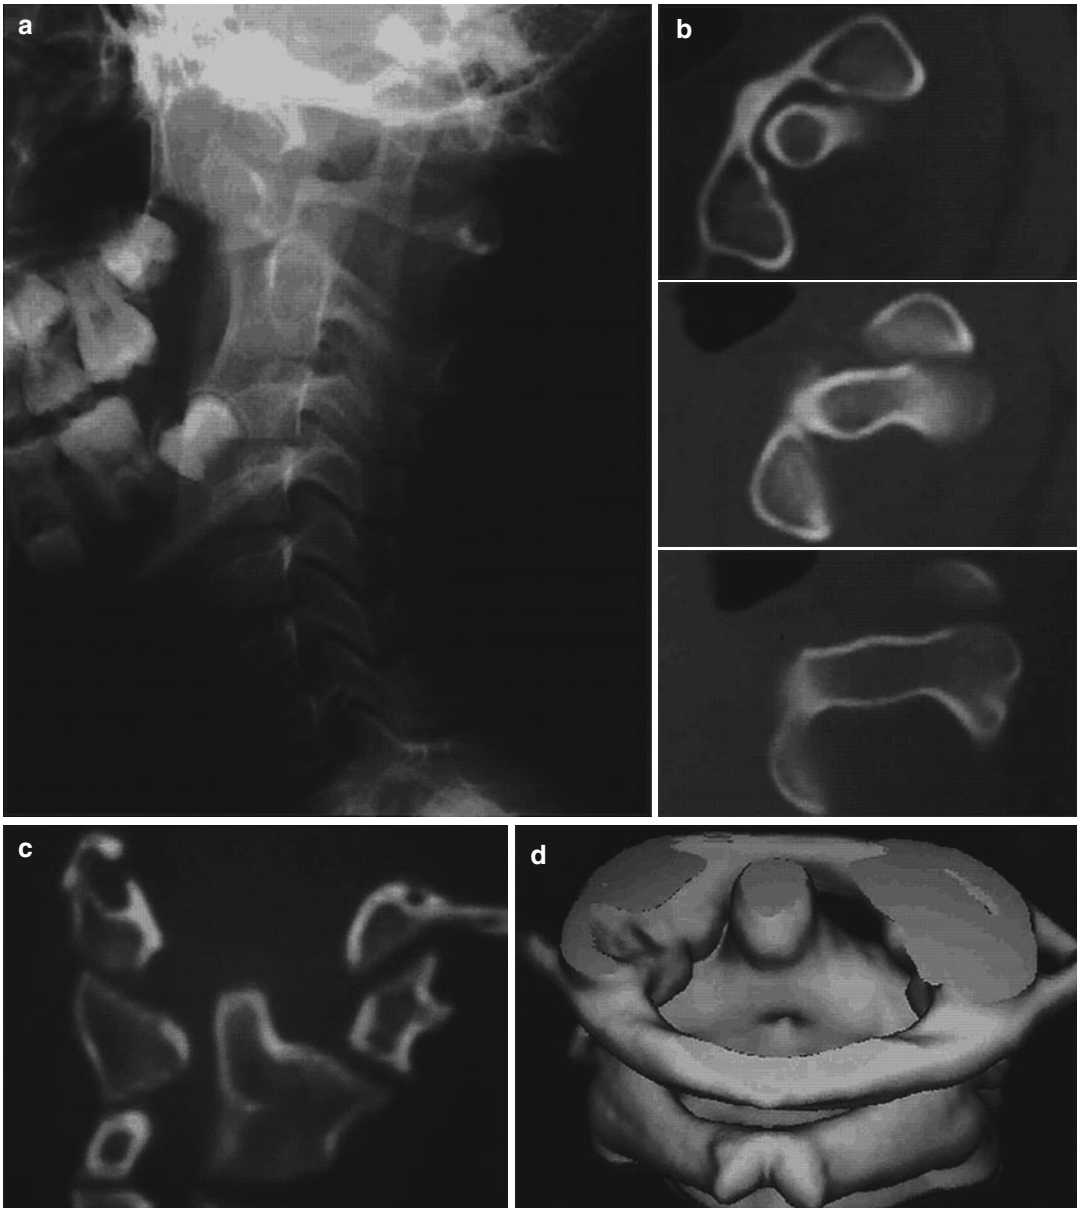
Lateral radiograph of the cervical spine (a), axial CT scans (b), coronal CT scan (c), and 3D reformatted CT scan (d) through C1 and C2 in a 12-year-old girl
